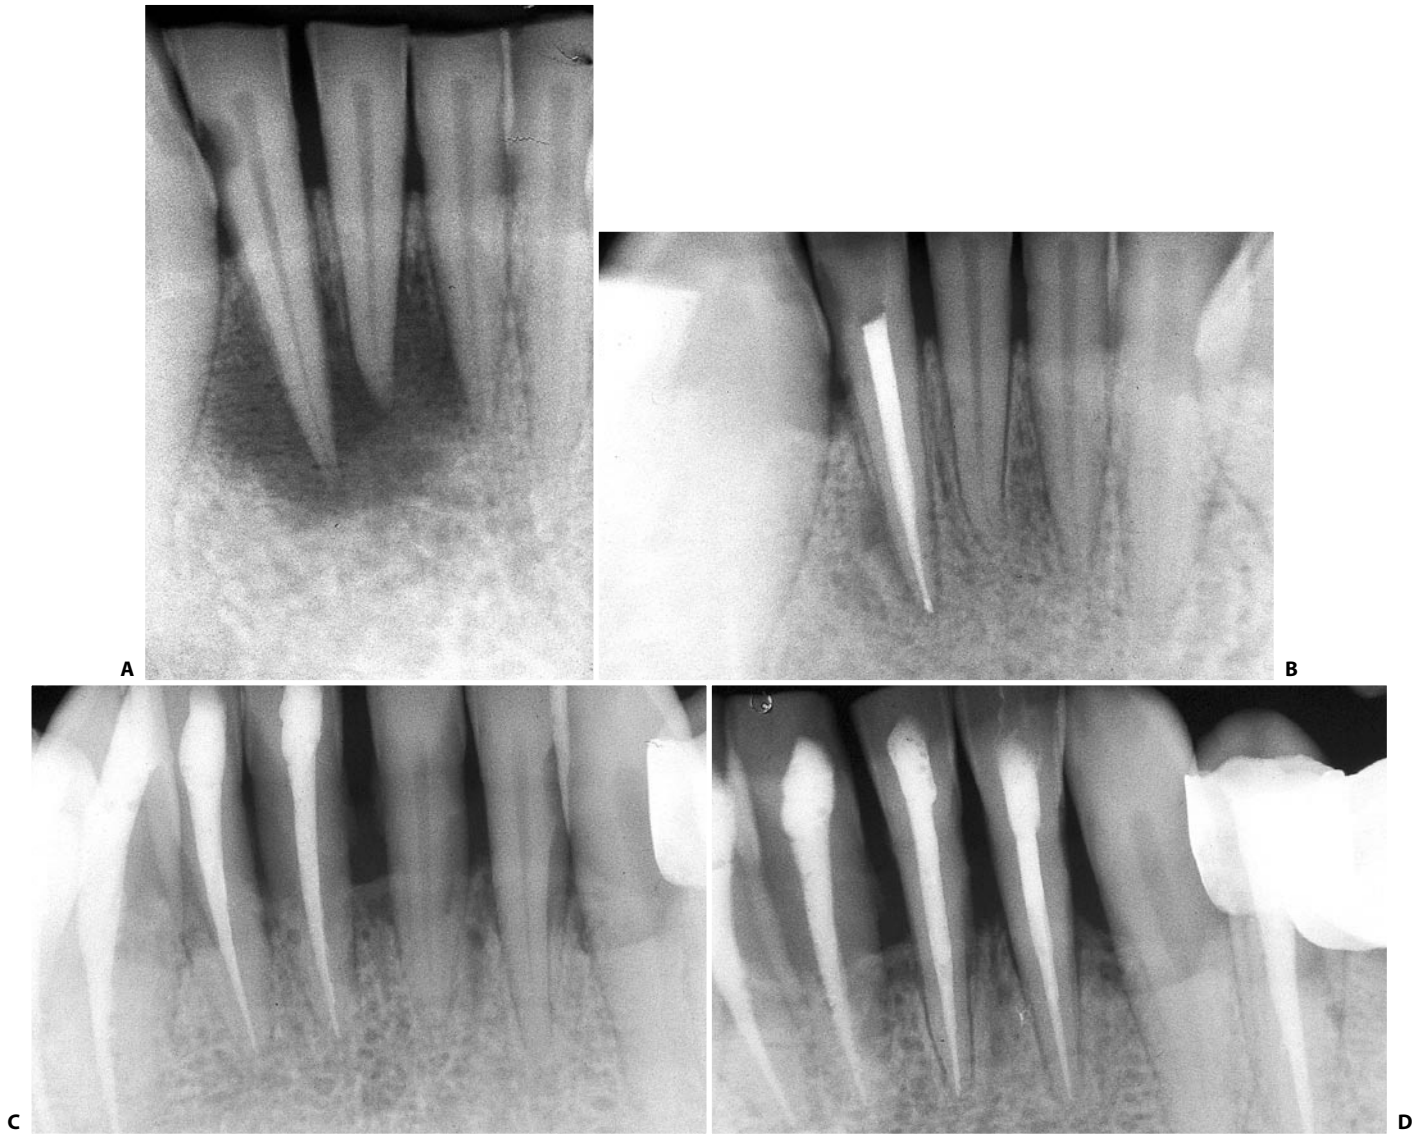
A. Preoperative radiograph. The lateral incisor is several millimeters longer than the central incisor. B. Recall radiograph 3 years later. C. The right lateral incisor reveals a single canal. D. The left lateral incisor of the same patient also reveals a single canal.
